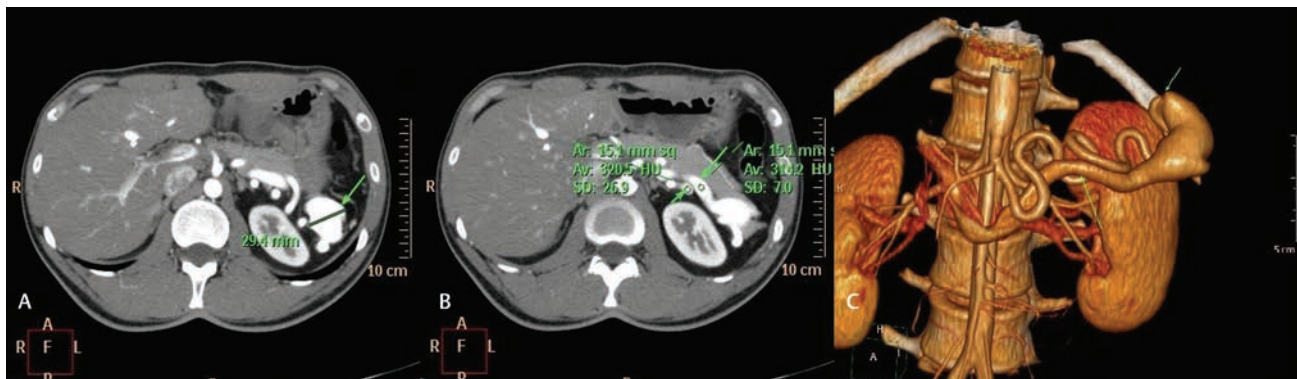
(A–C) Contrast-enhanced computed tomography (CT) showed aneurysm with a maximum diameter of 30 mm on the distal part of the tortuous splenic artery and splenic arteriovenous fistula and early opacification of the splenic vein. (C) Three-dimensional CT reconstruction revealed aneurysm and connection between the splenic artery and vein. A, anterior; Av, average; F, front; L, left; P, posterior; R, right; SD, standard deviation.
